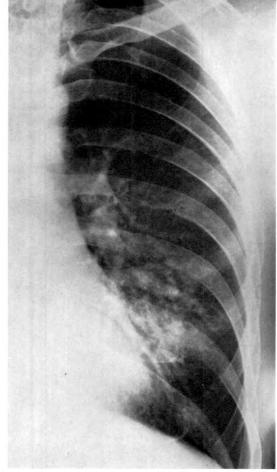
Same patient as shown in Figure 6. This posteroanterior roentgenogram, made 5 years later, shows that the lesion in the left upper lobe has cleared satisfactorily, but that now there is diffuse involvement of the left lower lobe.
